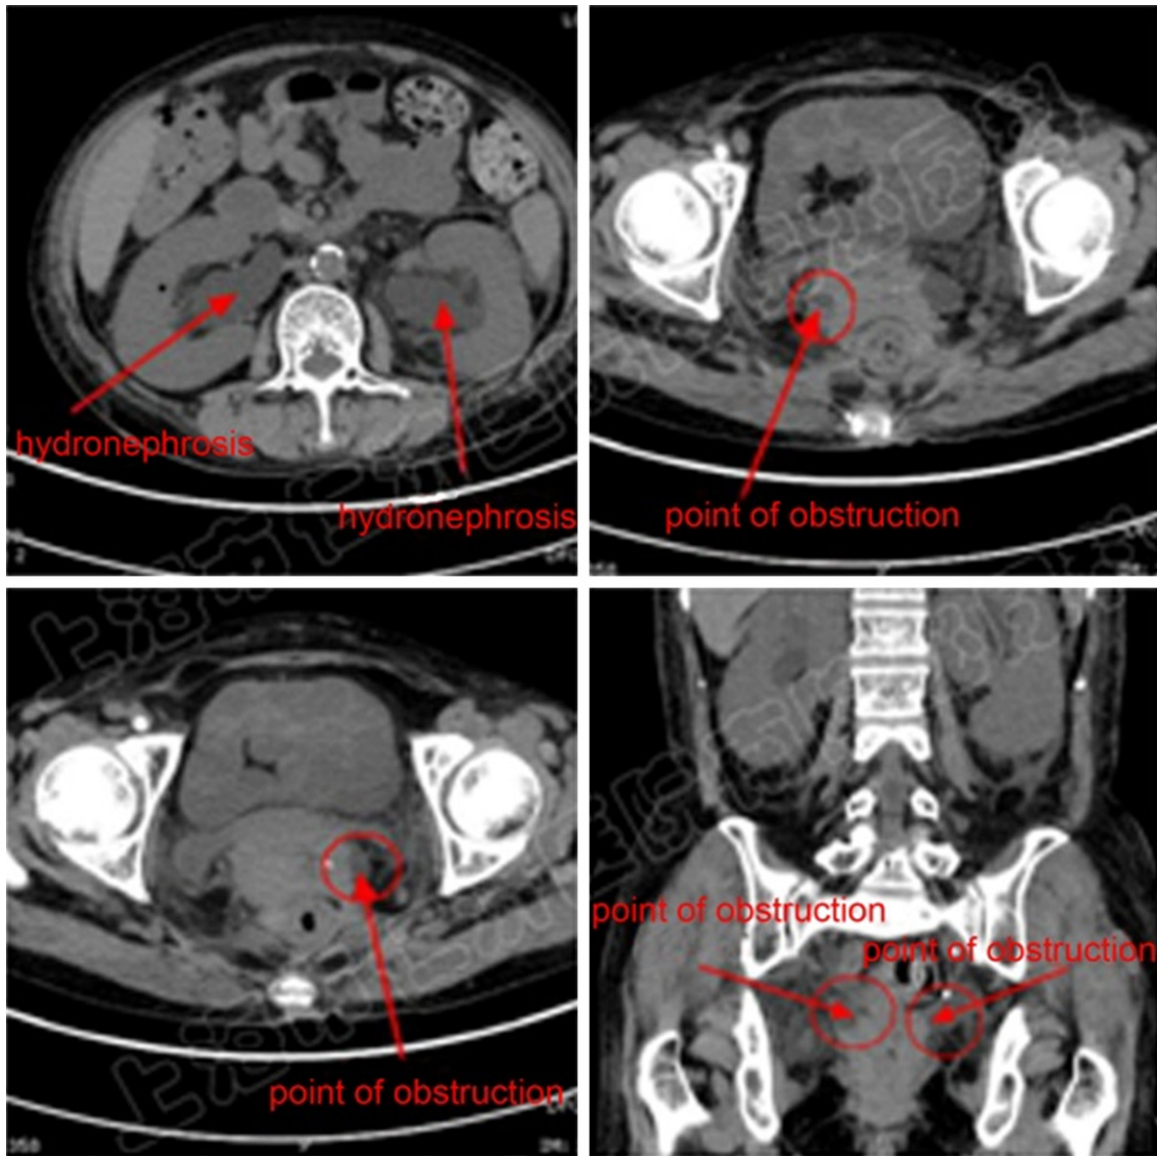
CT image of the patient with ureteric obstruction caused by advanced cervical cancer.
